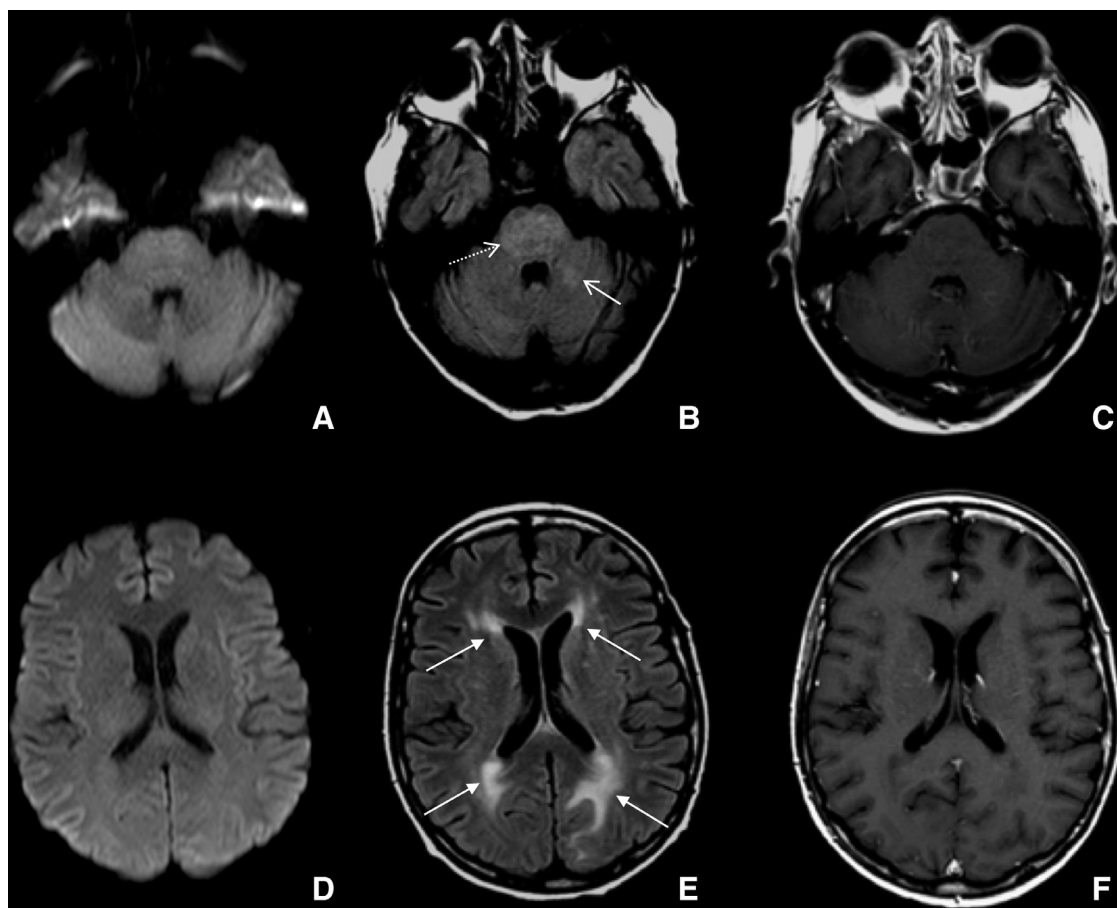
Posterior Reversible Encephalopathy Syndrome signs at MR examination. Diffusion weighted imaging (A and B), T2-FLAIR (C and D), T1 after administration gadolinium-based contrast agent (E and F). The exam showed T2-hyperintensity in the pons (short open arrow in C), left brachium pontis (long open arrow in C), and in the periventricular and subcortical white matter (close arrows in D). No enhancing or anomalies on the Diffusion Weighted Imaging were detected. These findings are highly suggestive for PRES.
